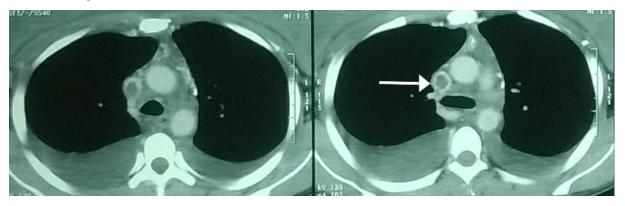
Contrast enhanced computed tomography(CECT) thorax showing superior vena cava thrombus.
